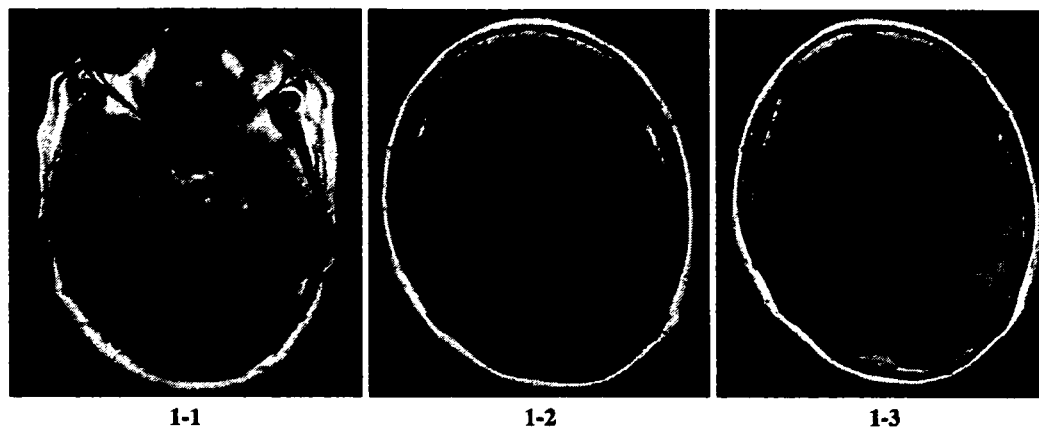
Magnetic resonance images on admission. FLAIR images show high-intensity lesion in the brainstem (1-1), right thalamus and caudate nucleus (1-2) at first hospitalization, and high-intensity lesion in the cortex and subcortical white matter of the left temporal lobe at second hospitalization (1-3).
